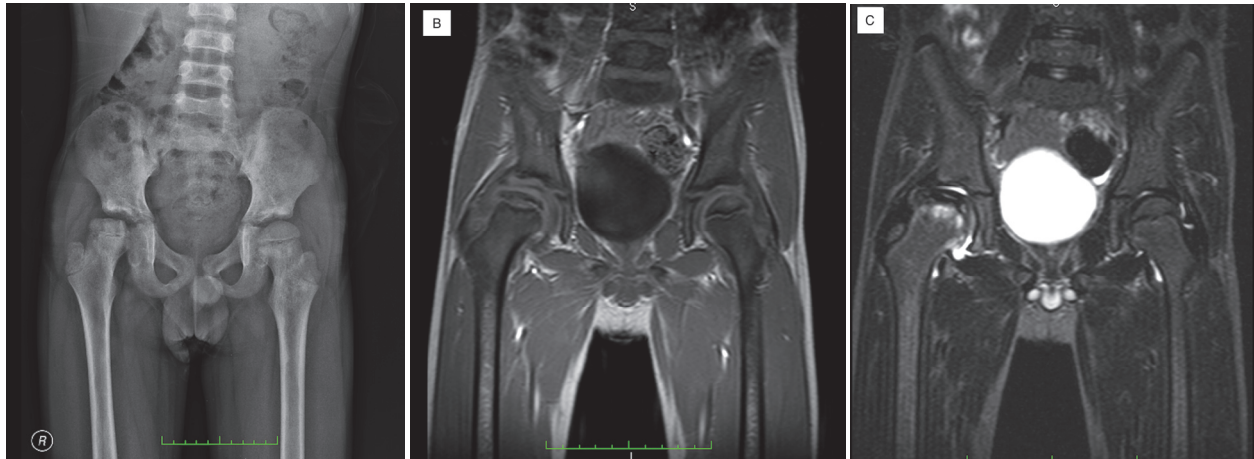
Anteroposterior plain radiography shows sclerosis, loss of height and irregularity on the head of femur of the right hip. The coronal T1 weight MRI shows loss of epiphyseal height, synovitis on the right hip (B) edema in metaphysis on coronal fat sat T1 image (C).
